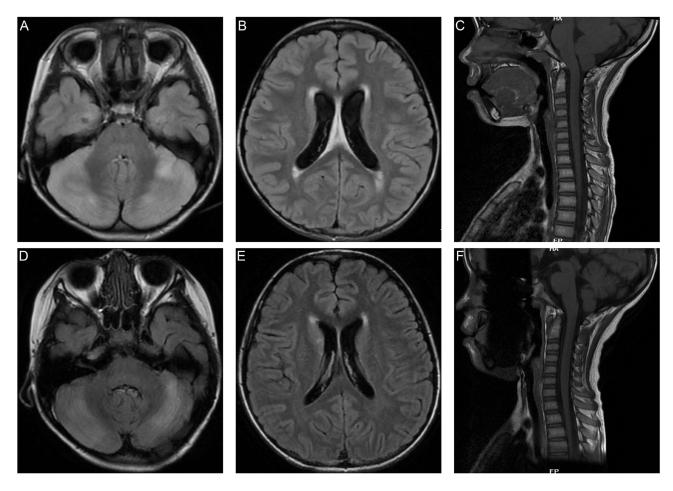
Figure I Brain images of case I. (A–C) Initial brain images of the patient. (A) Hyperintensity and swelling of Cerebellum in T2-weighted fluid attenuated inversion recovery (T2FLAIR). (B) Hyperintensity around lateral ventricles and enlargement of lateral ventricles in T2FLAIR. (C) Cerebellar tonsillar herniation in T1 sequence. (D–F) Brain images after treatment. (D) Remaining existence of Hyperintensity in Cerebellum. (E) Reduced hyperintensity around lateral ventricles. (F) Resolved cerebellar tonsillar herniation and predominant cerebellar atrophy.
